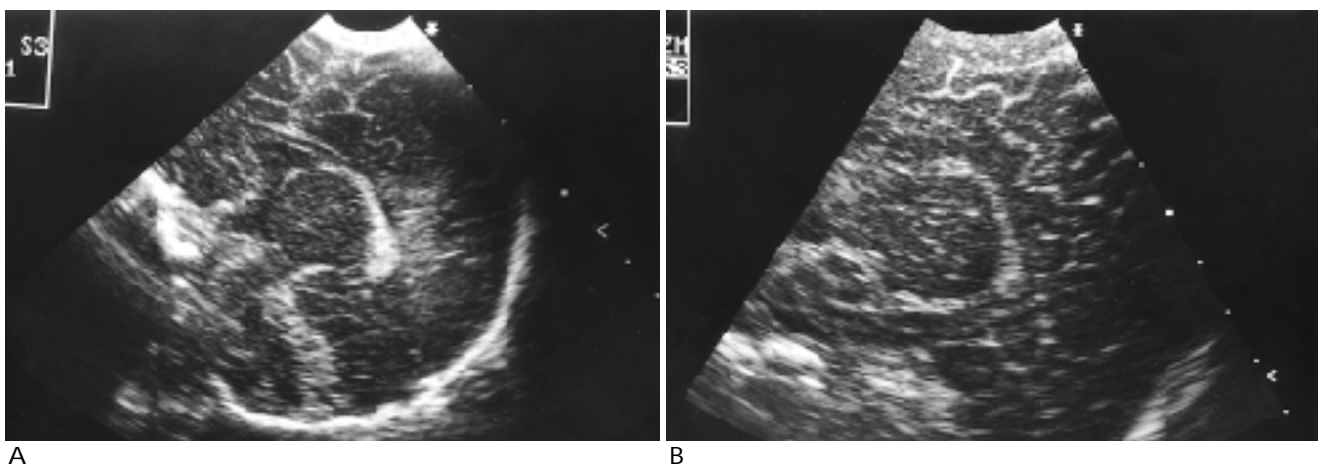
Oblique parasagittal scans of brain sonography in normal full-term infants show smooth tapering of anterior end of the choroid plexus(A) and anterior clubbing(B).
